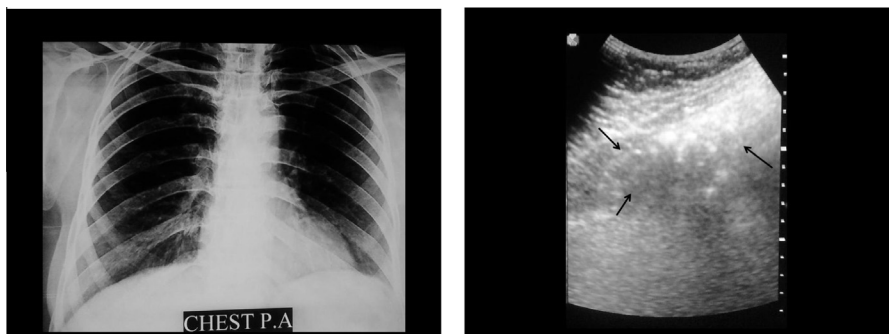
(a) Chest X-ray showed no remarkable findings in patient with suspected pneumonia. (b) Longitudinal US image at upper half of the lateral area of Rt lung showed homogenous area of consolidation containing air bronchogram.
